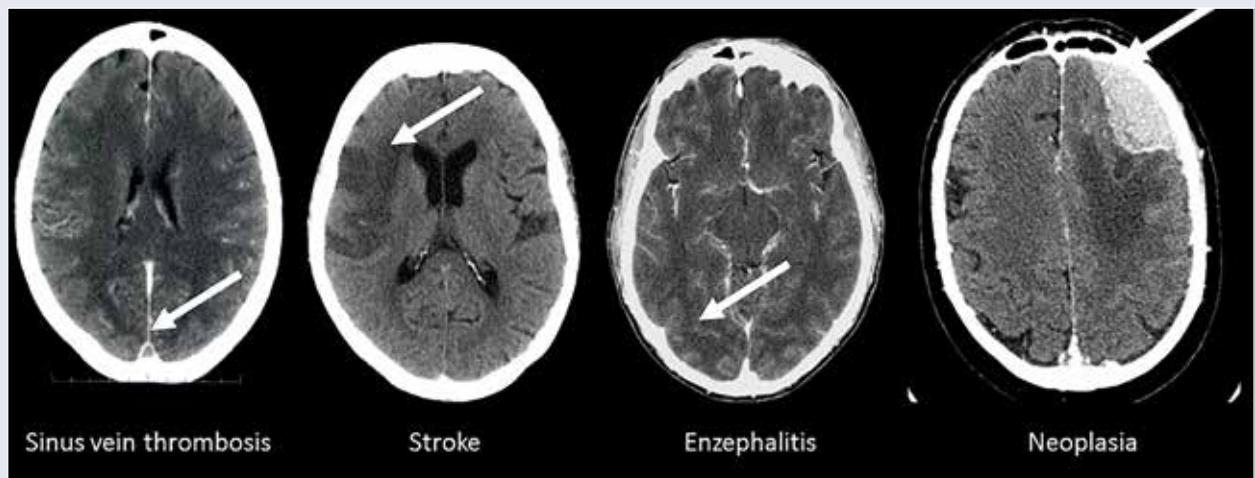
Causes of acute symptomatic seizure. Left: Contrast-enhanced CT-image depicting a thrombus within the superior sagittal sinus. 2nd image left: Acute stroke in the media territory of the right side visualised by hypodense demarcation of parenchyma on unenhanced CT. 3rd image left: Contrast enhanced CT with extravasation of contrast agent in the subarachnoidal space as correlate of blood-brain-barrier dysfunction in meningoencephalitis. Right: Right frontal contrast-enhancing extraaxial tumor suggesting meningioma.
